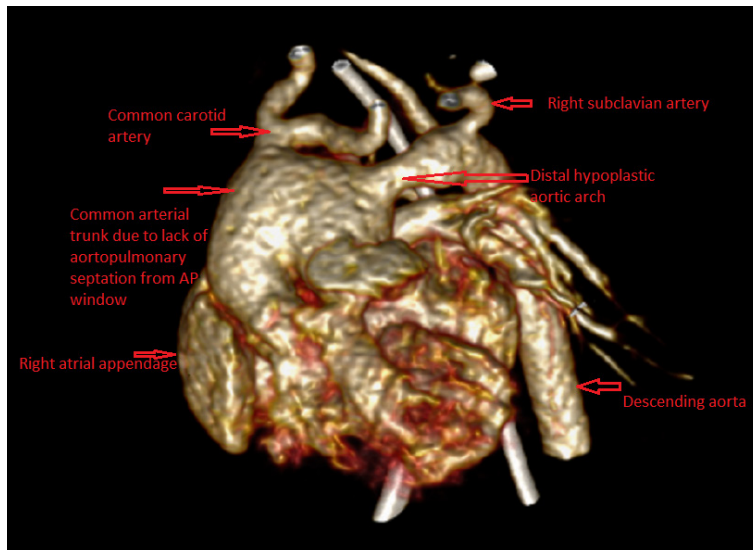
Reconstructed CT image anterior projection showing head and neck vessels and AP window in detail.
